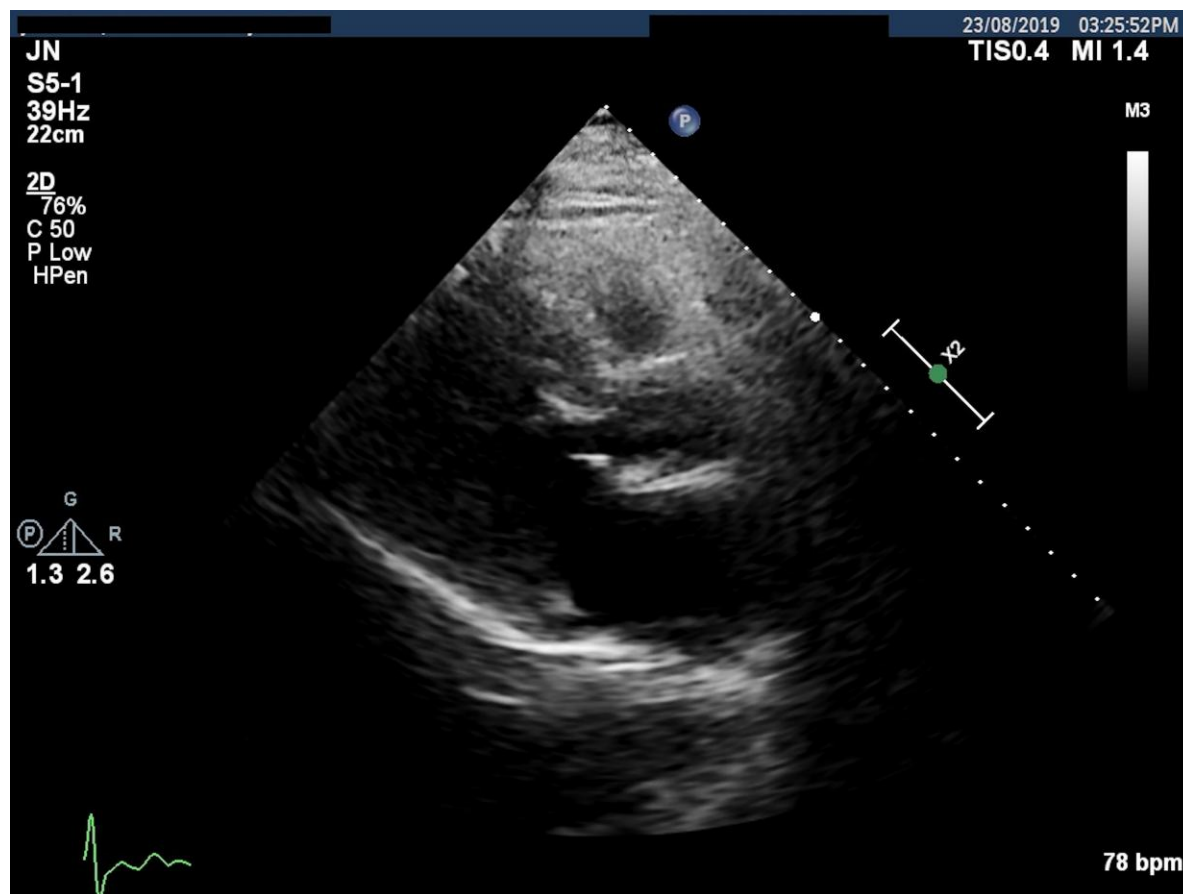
Echocardiogram parasternal long-axis image showing the hypertrophied interventricular septum; no clear binary appearance of the left ventricular border.
